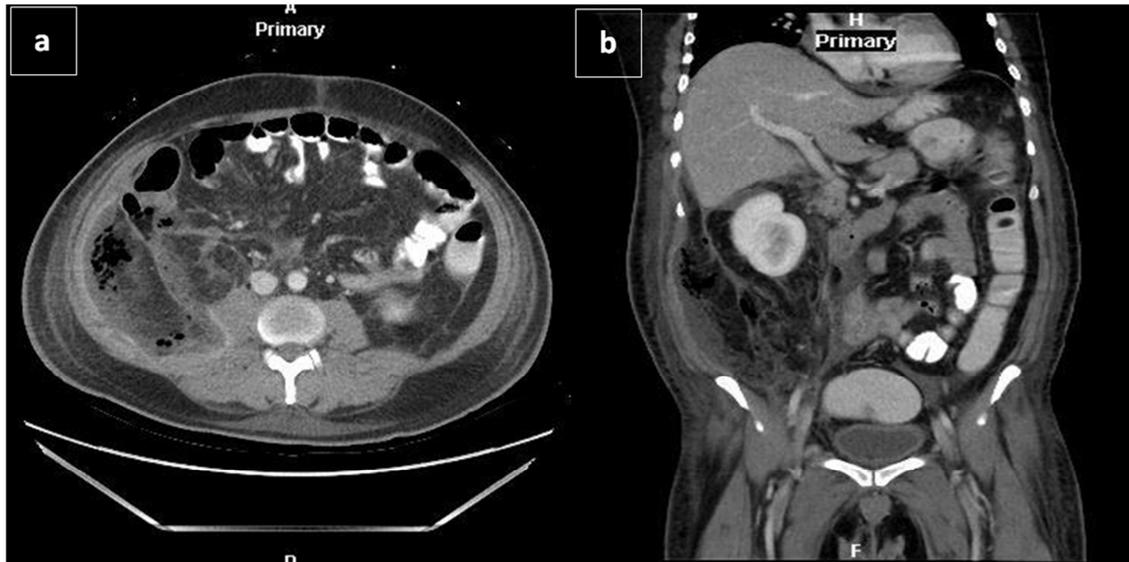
Abdominopelvic Computed Tomography (CT) with contrast of post-laparoscopy day#6, (a) axial and (b) transverse plane, revealing a progressive course of the complicated inflammatory process as well as of the multiple variable sizes ill-defined fluid collections.
